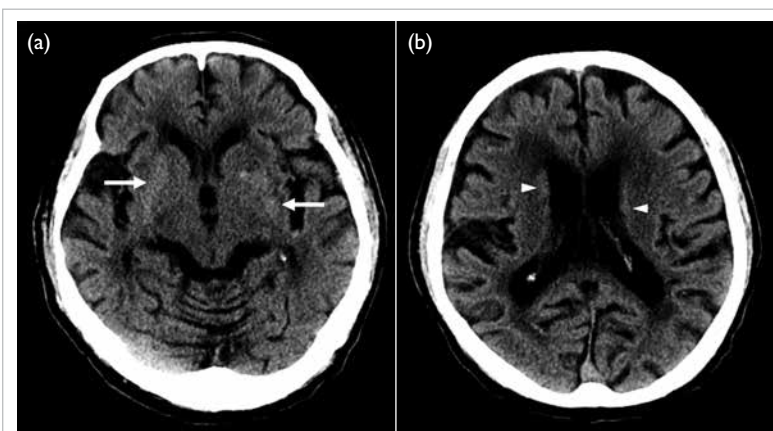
Case 2. Non-contrast computed tomography of the brain showing asymmetric subtle hyperdensity in bilateral putamen (a) [arrows] and bilateral caudate nuclei (b) [arrowheads], more extensive on the right, without mass effect or surrounding oedema, in keeping with non-ketotic hyperglycaemic hemichorea
